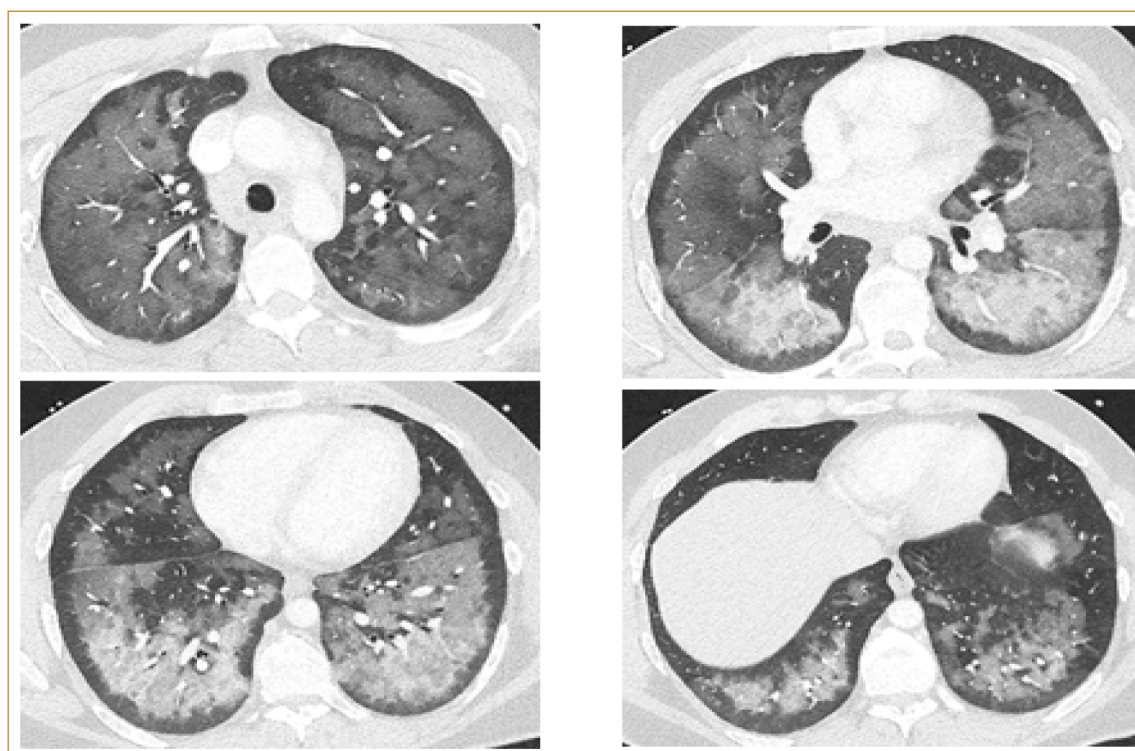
CT Thorax on admission demonstrating extensive bilateral pulmonary infiltrates representing severe acute waterproofing spray-associated pneumonitis
